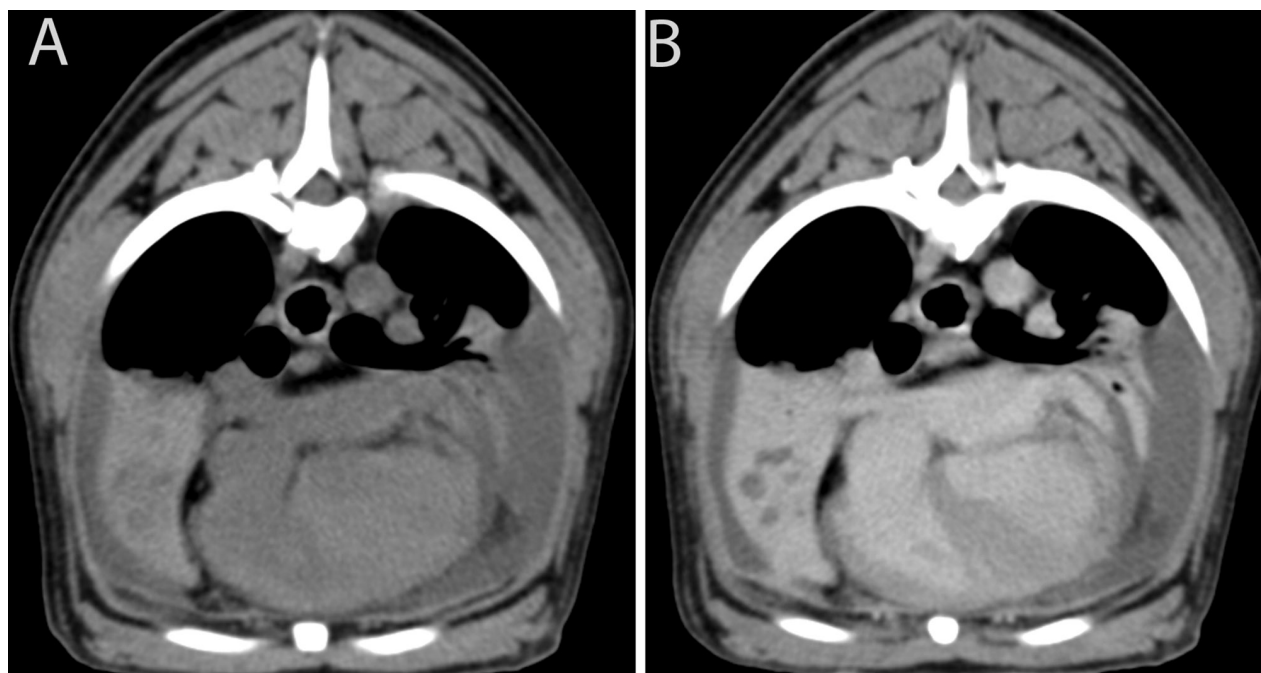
Transverse thoracic CT images at the level of the right middle lung lobe obtained before (A) and after (B) administration of contrast medium to a 4-year-old 10-kg (22-lb) spayed female French Bulldog referred because of pleural effusion and aspiration pneumonia following treatment (induction of emesis and oral administration of activated charcoal) of an accidental overdose of trazodone that occurred 19 days earlier. The patient was positioned in sternal recumbency, and the images are displayed in a soft tissue window (window width, 350 HU; window level, 40 HU).
